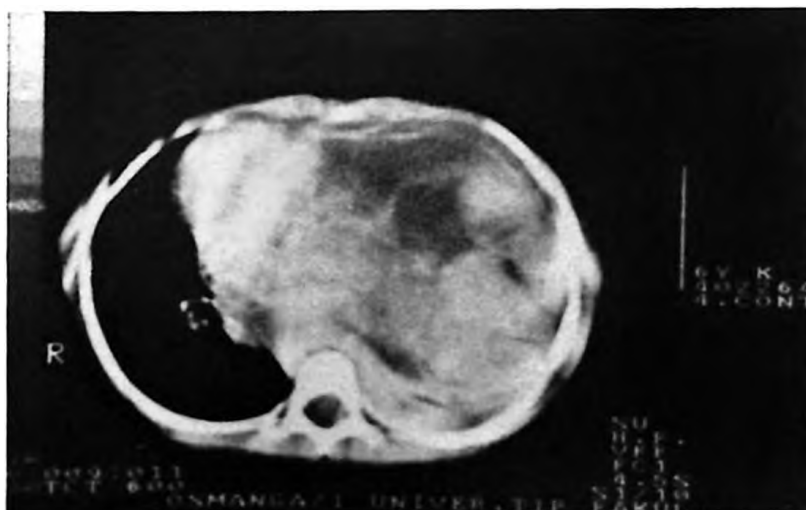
CT scan of the chest shows a large mass consisting of heterogeneous hyperdense and hypodense areas representing solid and cystic components within the left chest region.
